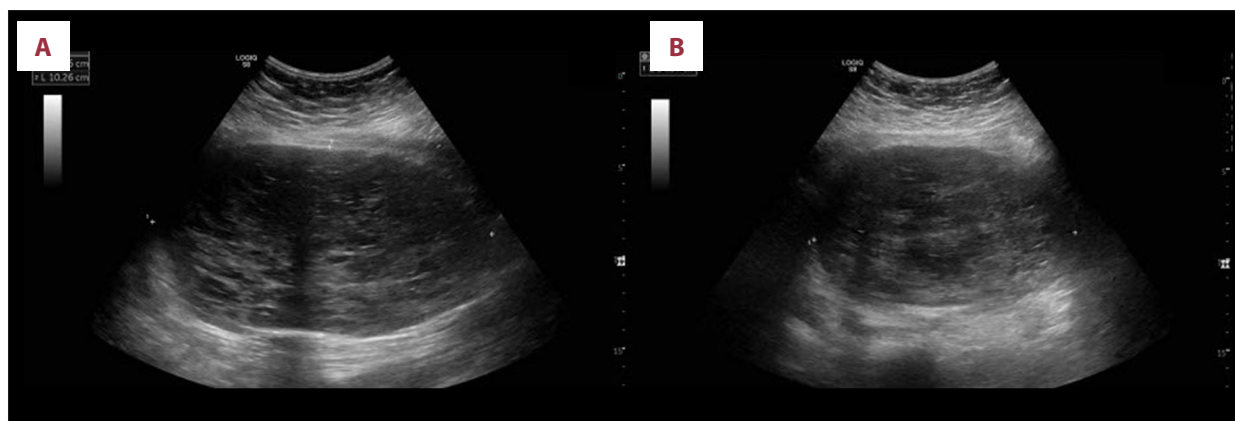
External transpelvic ultrasound of a heterogeneous, predominantly solid pelvic mass. (A) Sagittal view of the mass, measuring 18.6×10.3 cm. (B) Transverse view of the mass, with its height measuring 14.4 cm.
